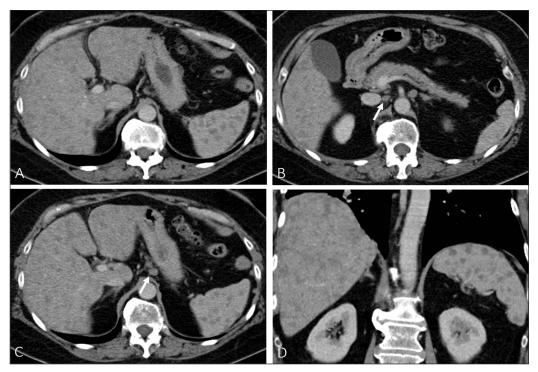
Axial (A, B, and C) and coronal (D) contrast-enhanced CT of the abdomen in the portal venous phase at time of the initial diagnosis. (A) shows multiple hypodense lesions throughout the liver and the spleen. (B) and (C) demonstrates lymph nodes of intermediate size (white arrow) at the retroperitoneum and along the lesser curvature of the stomach. The liver is slightly enlarged.
